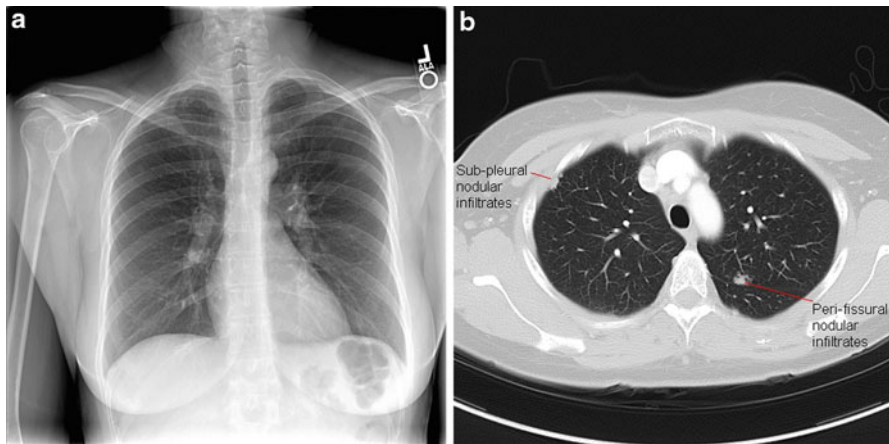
(a) Chest X-ray depicting mild mediastinal lymphadenopathy. (b) Computed tomography of the chest depicting nodular infiltrates
